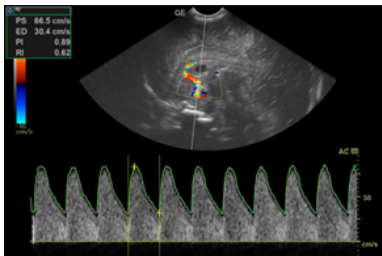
Spectral doppler analysis of ACA in a term neonate at 37weeks with low APGAR score and moderate HIE.
